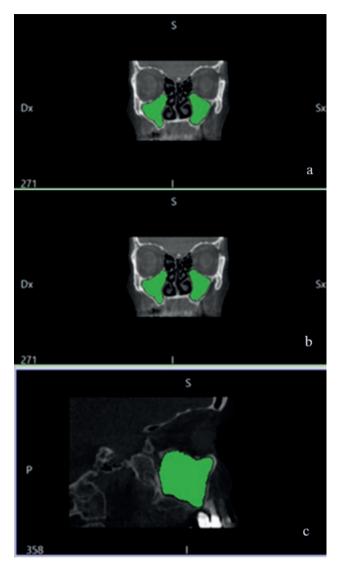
a. CBCT frontal section of the maxillary sinus; b. CBCT axial section of the maxillary sinus; CBCT sagittal section of the maxillary sinus.
